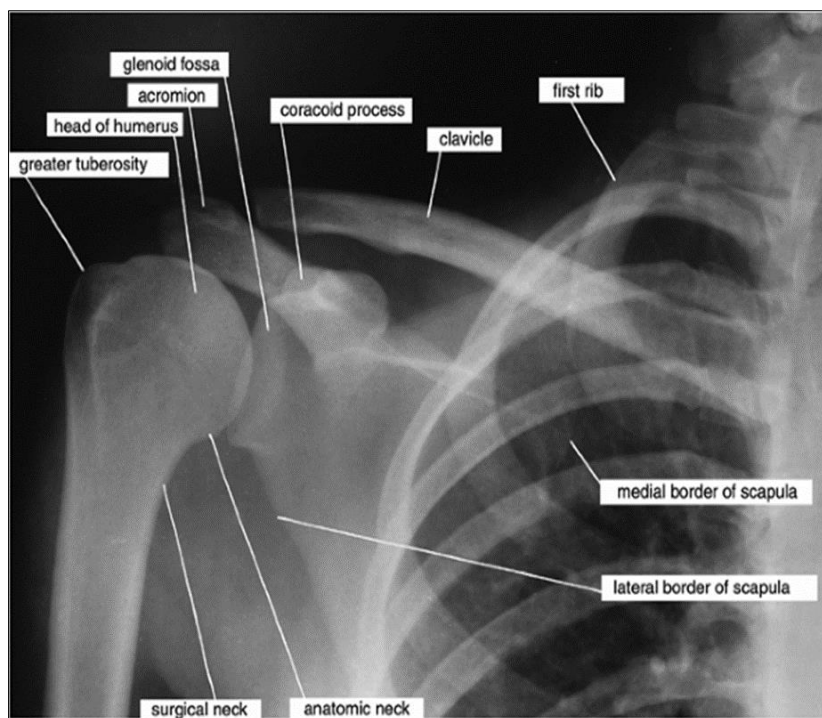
Plain X-ray of the proximal Upper limb
